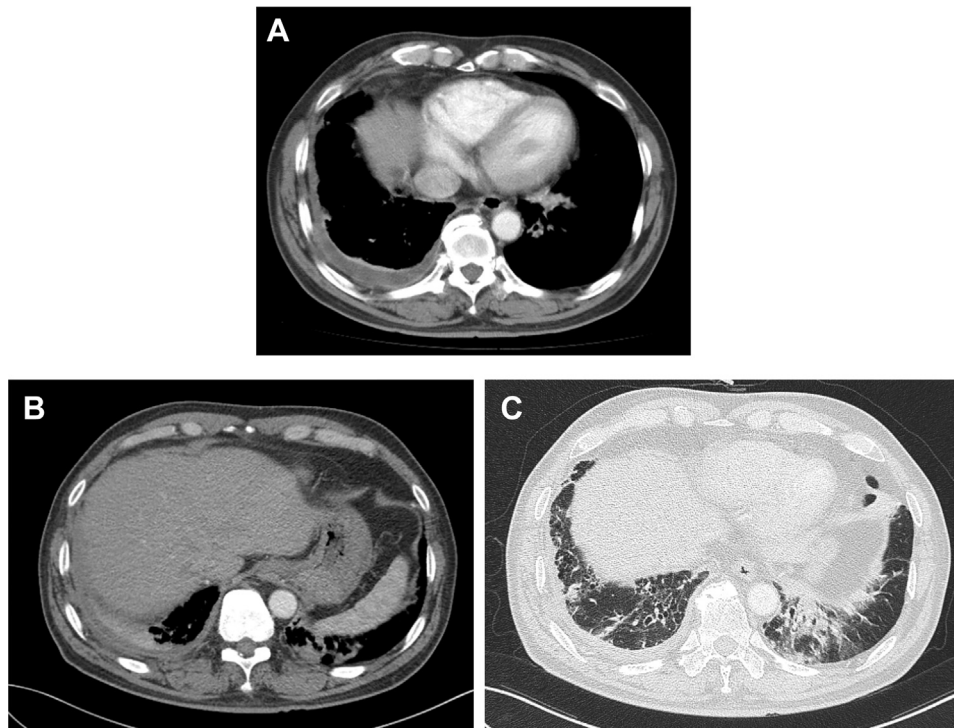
(A) Enhanced outside-chest CT image shows a small volume of right pleural effusion with pleural enhancement. (B, C) Follow-up enhanced axial CT findings revealed a decrease in the volume of right pleural effusion relative to the observed in the outside-chest CT image. (C) Bronchiectasis with bronchial wall thickening and mucoid impaction are observed in the both lower lobes. There were peribronchial and subpleural consolidations in the both lower lobes.
